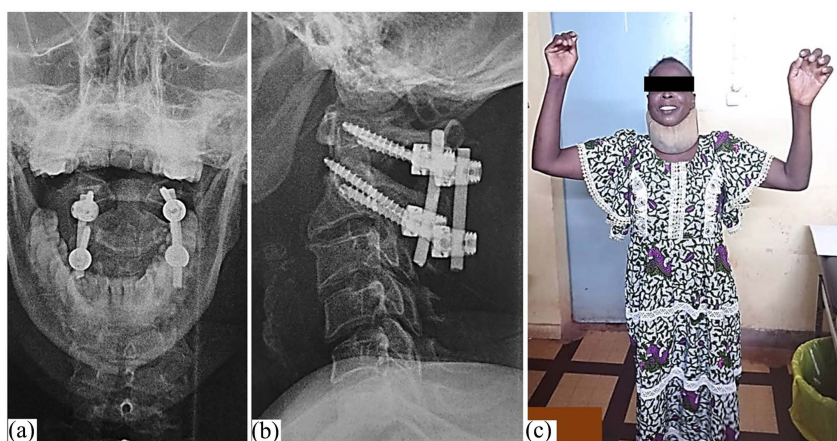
Case 1 Postoperative Xray showing proper reduction of dislocation after screwing ((a), (b)) and the patient at 45 postoperative days (c).
